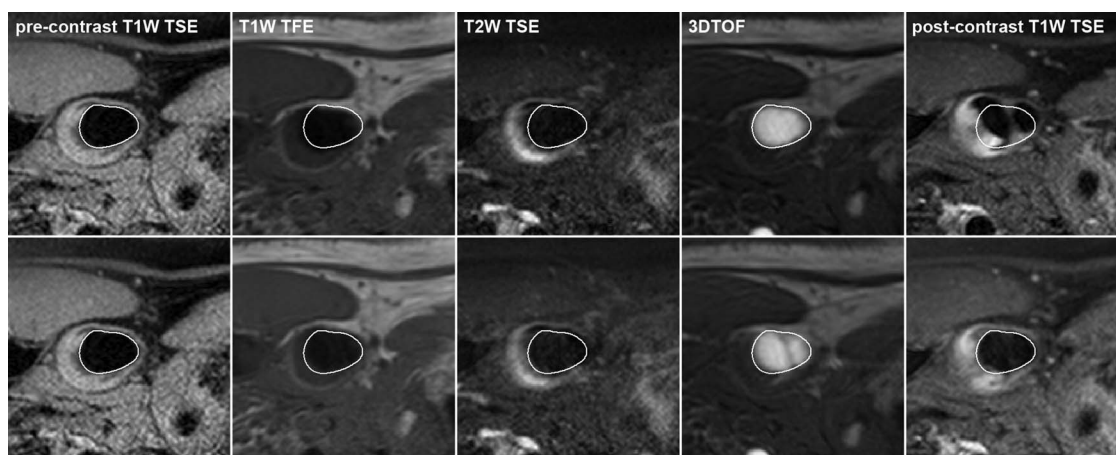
Example of MRI images before (top row) and after registration by the optimal 3D B-spline transformation (bottom row). The fixed image is shown in the first column. The lumen contour of the fixed image (white) is overlaid on all images. The postcontrast T1W TSE image shows that throughplane correction, which is achieved by using a 3D transformation model, is required for correct alignment.
